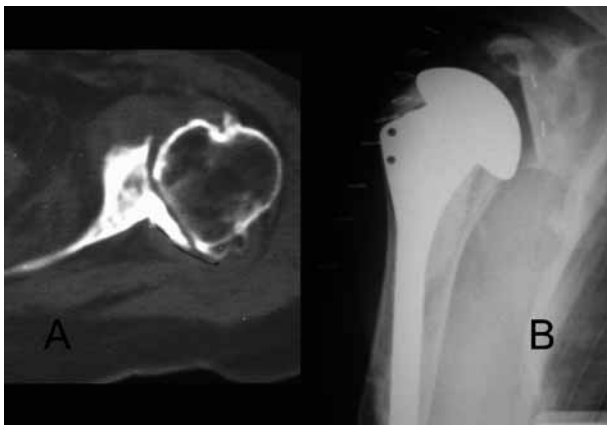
A 73-year-old woman with degenerative glenohumeral arthritis ; A. Preoperative CT scan of the left shoulder showing the arthritis and the large posterior osteophyte ; B. Postoperative true AP radiograph showing the normal relation between the prosthetic implant surfaces.
